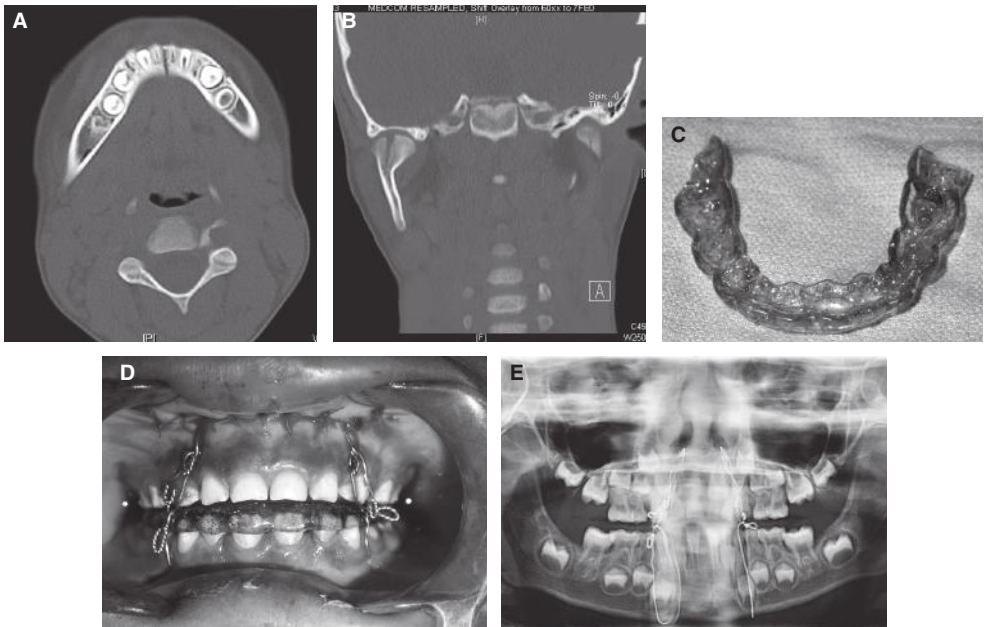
Pediatric mandible fracture at the symphysis and condyle with malocclusion. A and B, CT images of the fractures. C, Impressions are taken, models are made, model surgery is performed, and an occlusal splint is made. D, Piriform drop wires are placed, and the splint is secured to the mandible with circummandibular wires. Wire loops then connect the drop wires and the splint to secure IMF. E, Panorex image demonstrating the wiring technique.
